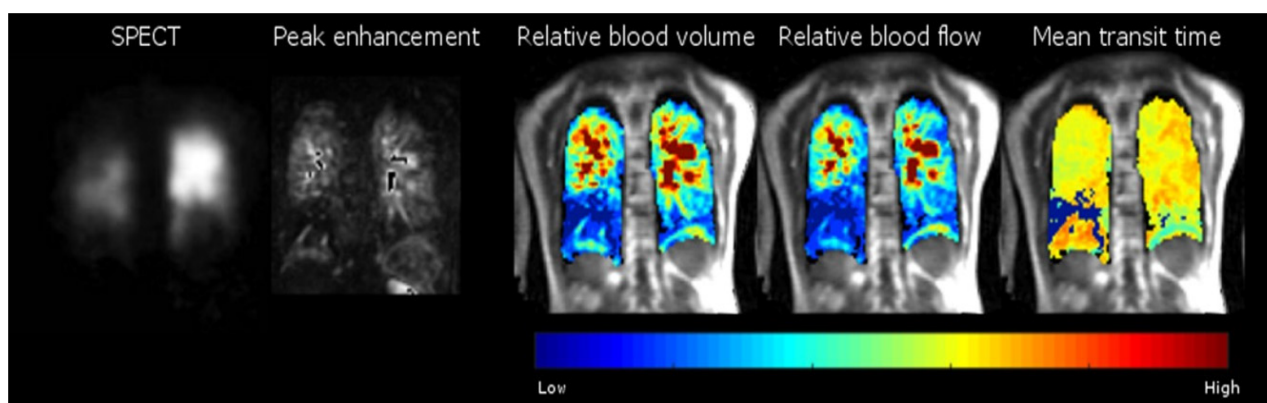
Comparing single photon emission computed tomography and dynamic contrast enhanced perfusion magnetic resonance imaging for identifying perfusion defects in chronic thromboembolic pulmonary hypertension patient. Left to right, single photon emission computed tomography and Perfusion magnetic resonance imaging (MRI) at peak enhancement of a chronic thromboembolic pulmonary hypertension patient showing perfusion defects in right and left lower lobes. On the right, semi-quantitative pulmonary blood flow, pulmonary blood volume & mean transit time maps acquired from perfusion MRI demonstrating reduced flow at the same locations. Note left to right scale depicting lower to higher pulmonary blood flow values. Citation: Johns CS, Swift AJ, Rajaram S, Hughes PJC, Capener DJ, Kiely DG, Wild JM. Lung perfusion: MRI vs. SPECT for screening in suspected chronic thromboembolic pulmonary hypertension. *J Magn Reson Imaging* 2017; 46: 1693-1697 [PMID: 28376242 DOI: 10.1002/jmri.25714].
